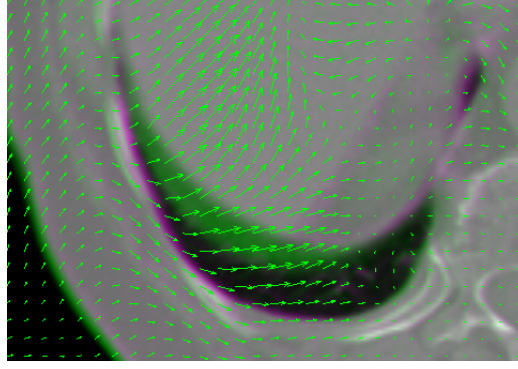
Image Registration: Two motion phases of a 4D-CT are shown in green and purple. The corresponding vector field, calculated using *Plastimatch*, is represented using green arrows.
